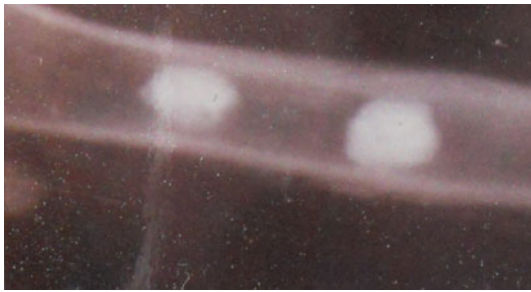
Radiograph taken soon after implantation with  $\text{TiO}_2$
